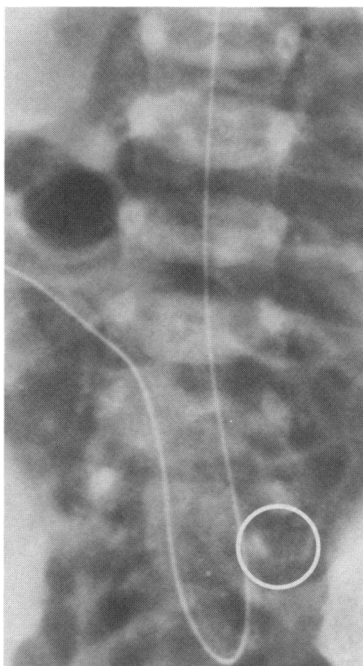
Neonatal radiograph showing the lumbar and sacral spine. An umbilical catheter has been placed. Multiple areas of perivertebral stippling are present. One such area is enclosed within the white circle. Stippling is more evident on the original radiographs than on this photographic reproduction.
